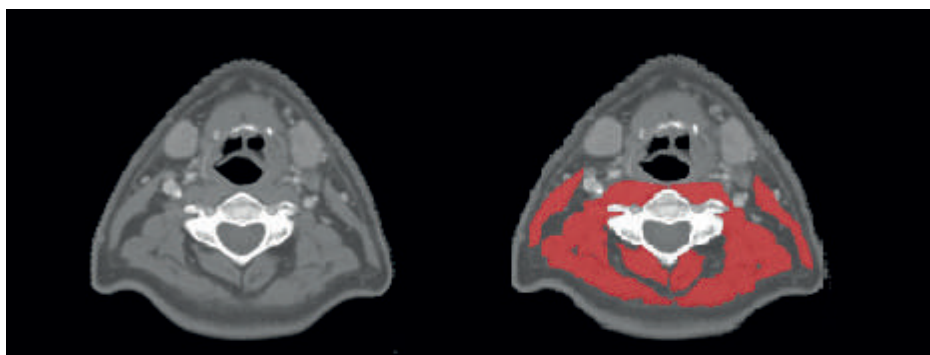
Figure shows two identical axial computed tomography (CT) slides at the level of C3; left shows the muscle tissue unsegmented, right shows both sternocleidomastoid and paravertebral muscles segmented in red.
